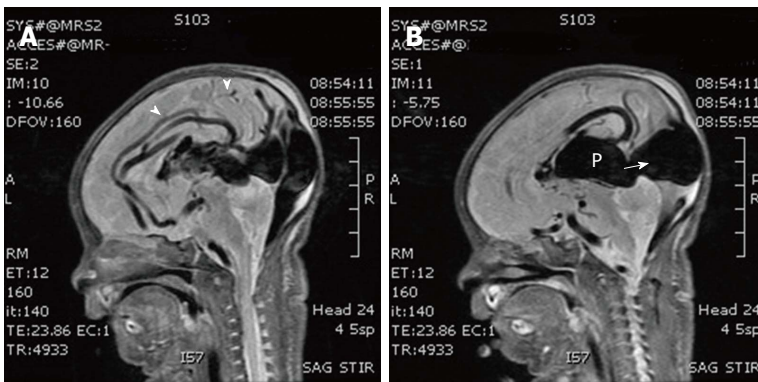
Sagittal T1-weighted magnetic resonance images show a choroidal type. Vein of Galen aneurysmal malformation with feeders (arrow heads, A) to arteriovenous fistulas, dilated prosencephalic vein of Markowski and persistence of the falcine draining sinus (white arrow, B).
